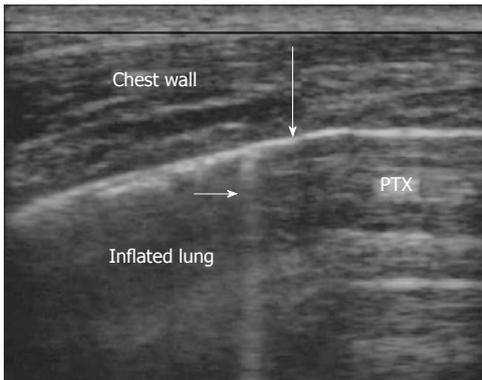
An ultrasound depiction of a pneumothorax is shown. This is the lung point. To the right of the image air blocks visualization of typical lung artifacts. On the left, the visceral and parietal pleura are sliding past each other. The large arrow shows where they meet. The small arrow shows a B line, seen only in inflated portions of the lung.
